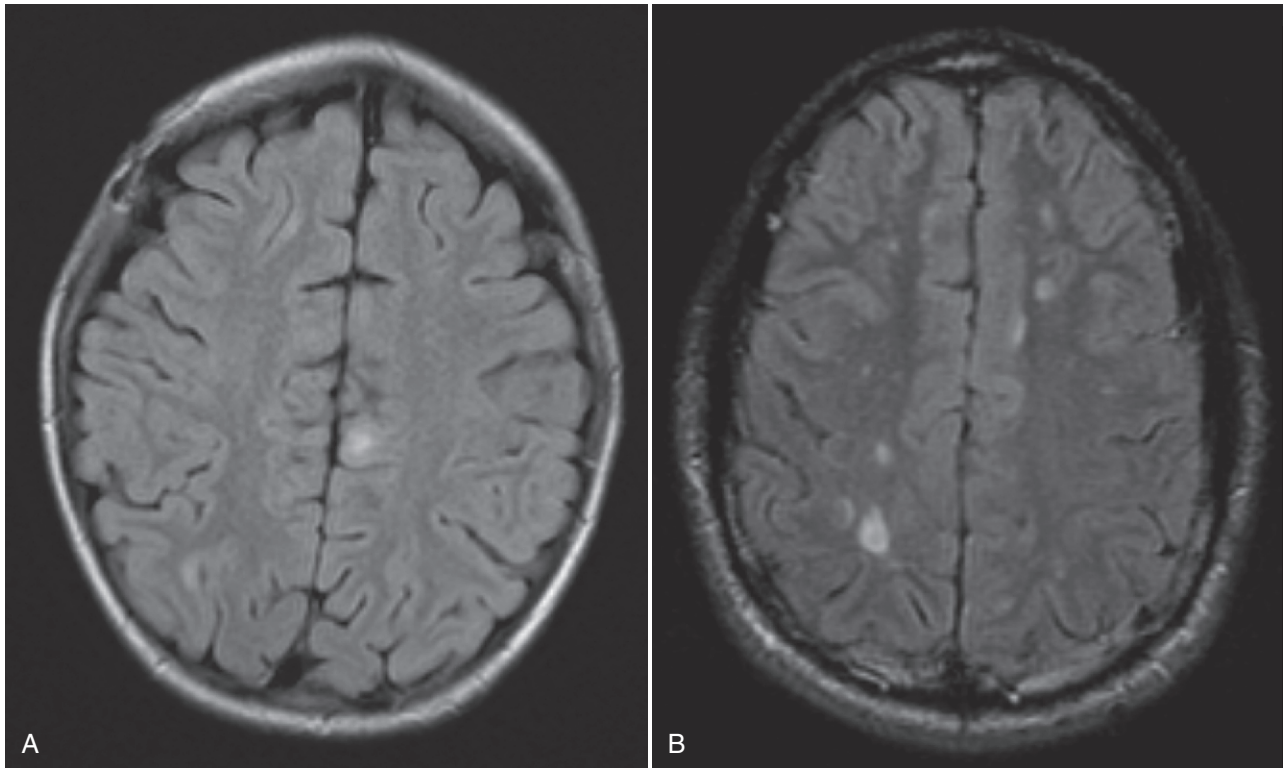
Radiographic overlap between multiple sclerosis (MS) and acute disseminated encephalomyelitis (ADEM). A, ADEM tends to have a single area of demyelination, often involving the cortical gray-white junction. This T2 fluid-attenuated inversion recovery (FLAIR) image shows involvement of the subcortical white matter. B, MS tends to involve the deep white matter and corpus callosum. This T2 FLAIR image demonstrates lesions in these areas.
